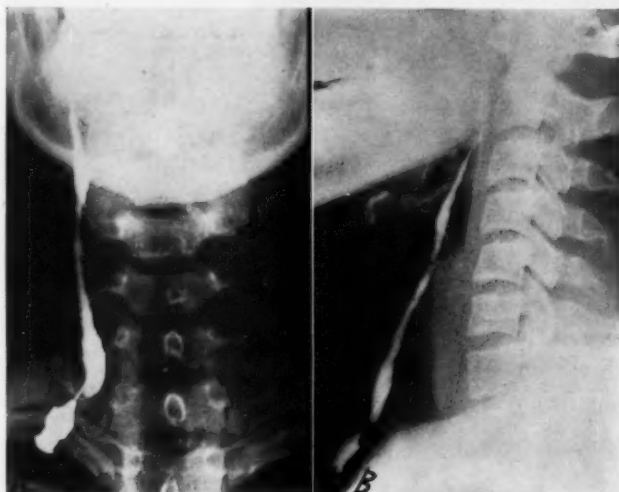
Radiographic study of complete lateral fistula. (A) The tract follows the course of thymic duct.
